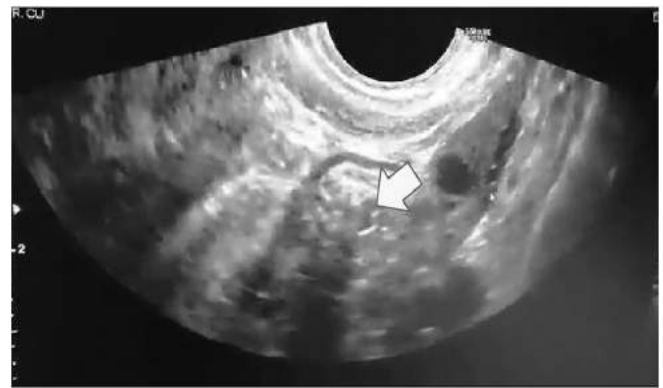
Transrectal sonogram showing the left ovary.
